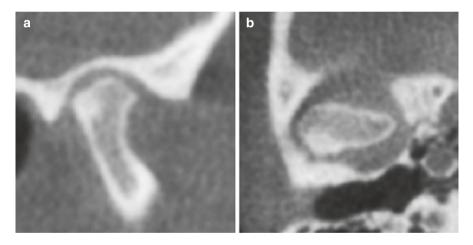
CBCT cross sections show a high-density exophytic bony lesion on the posterior surface of the condyle (a and b), suggestive of an osteoma. This currently has not caused anterior displacement of the condyle but could over time
